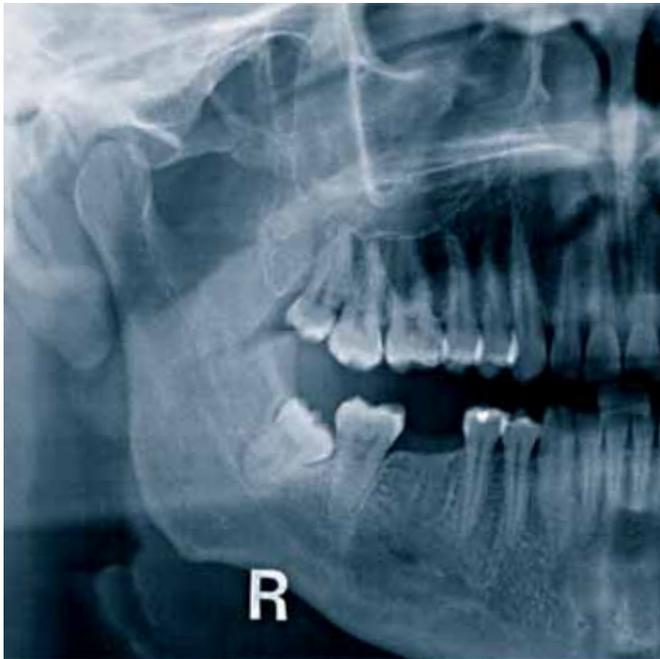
Panoramic radiograph six months post op.
